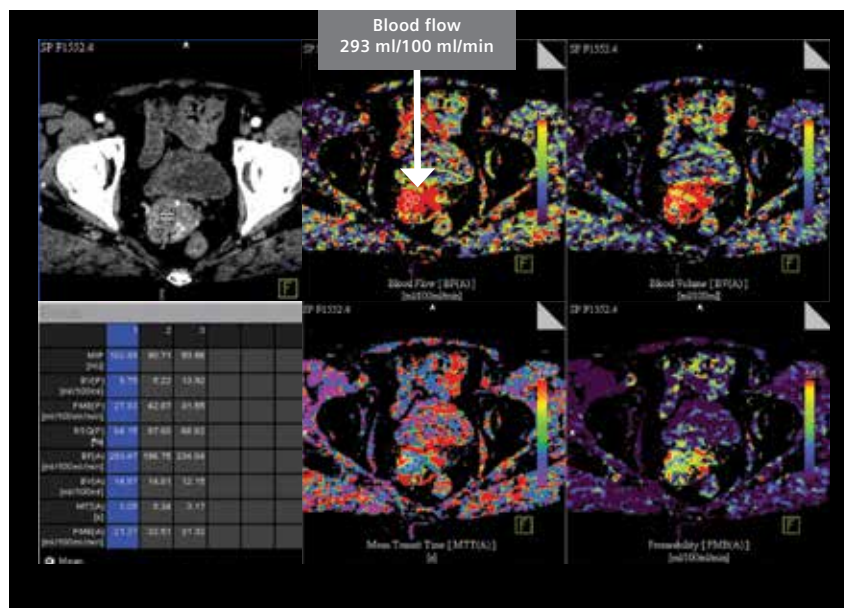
CT perfusion maps at the level of lower cervical mass also show very high blood flow (highest blood flow value of 293 ml/100 ml/min in ROI 1, white arrow).
